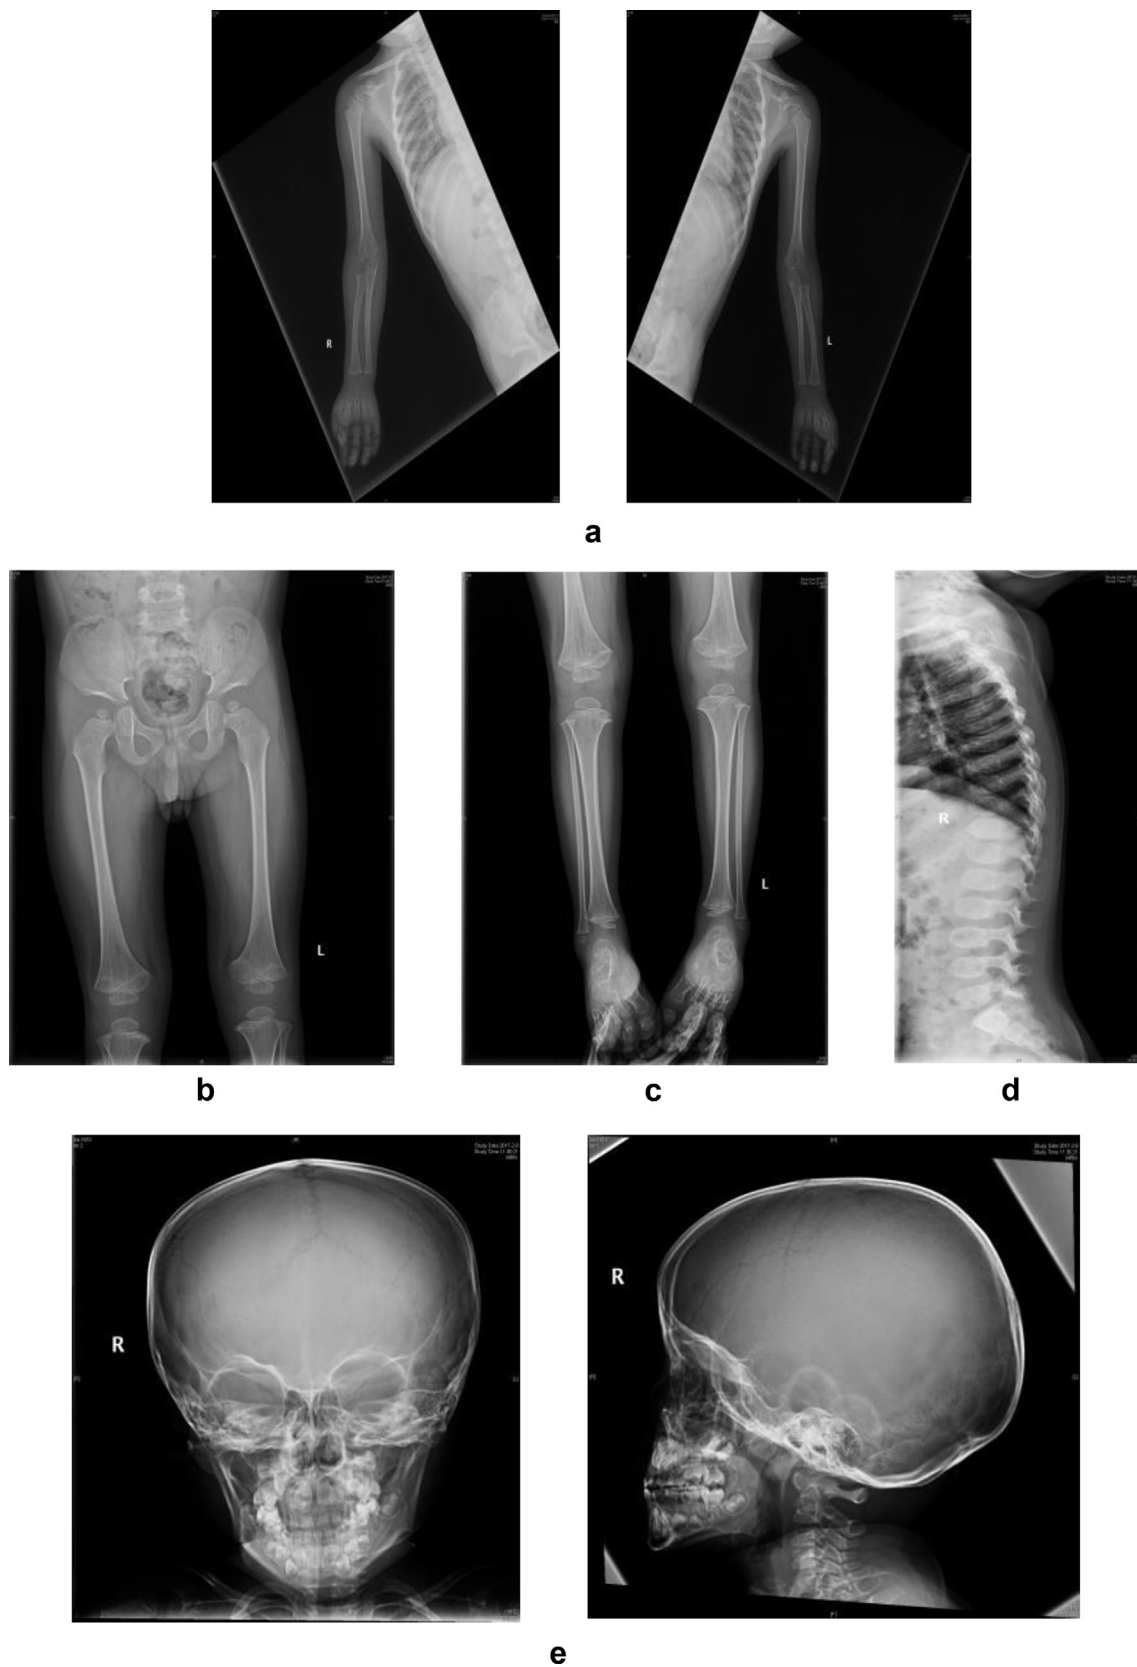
Radiographic findings of the patient: 1. Short tubular bones with irregular epiphyses and metaphyses (a,c); 2. Bilateral short and thick femoral neck, flattened femoral head (b); 3. Anterior tonguing or beaking of the vertebral bodies (d); 4. Normal skull(e).
